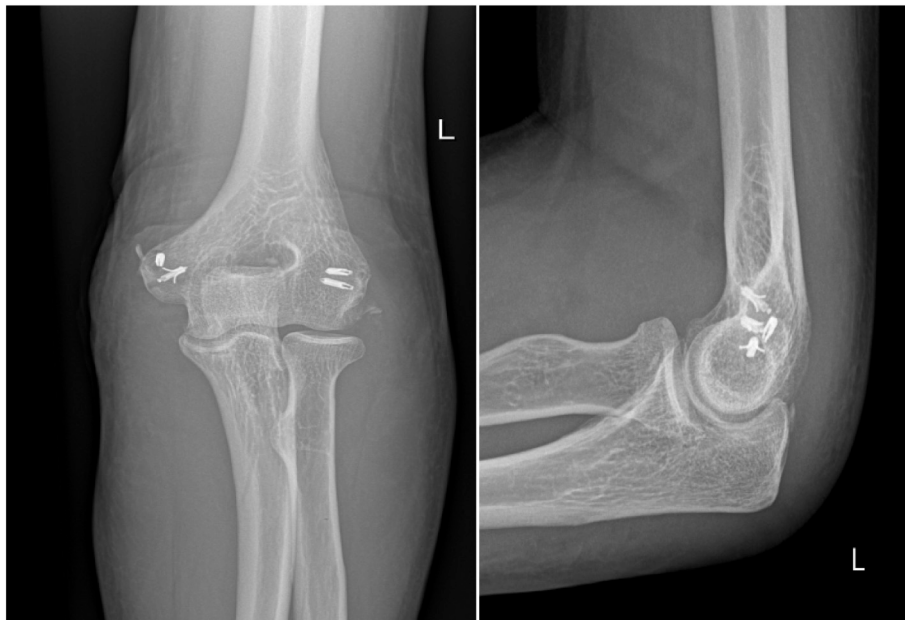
Plain radiographs after repair.
